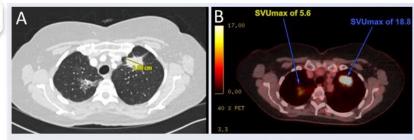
(A) Axial CT image of Twin 2 showing a spiculated solid nodule in the left upper lobe(LUL) and a subsolid lesion in the right upper lobe(RUL).(B) Corresponding PET-CT demonstrating intense FDG uptake in the LUL lesion and moderate uptake in the RUL lesion.
